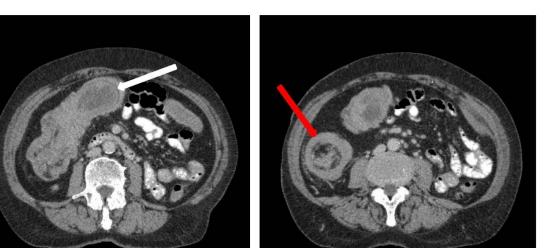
Computed Tomography abdomen and pelvis with oral contrast.
